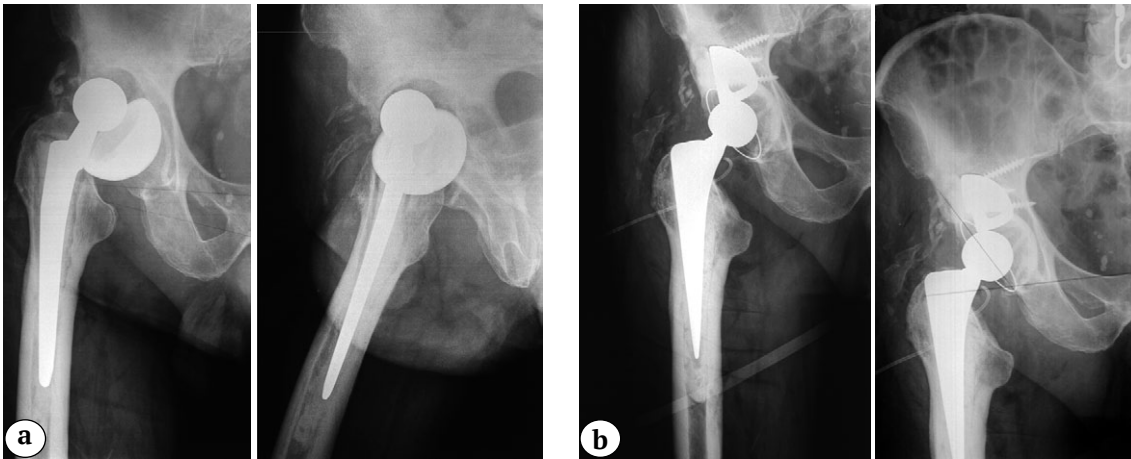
X-rays of the right hip:
